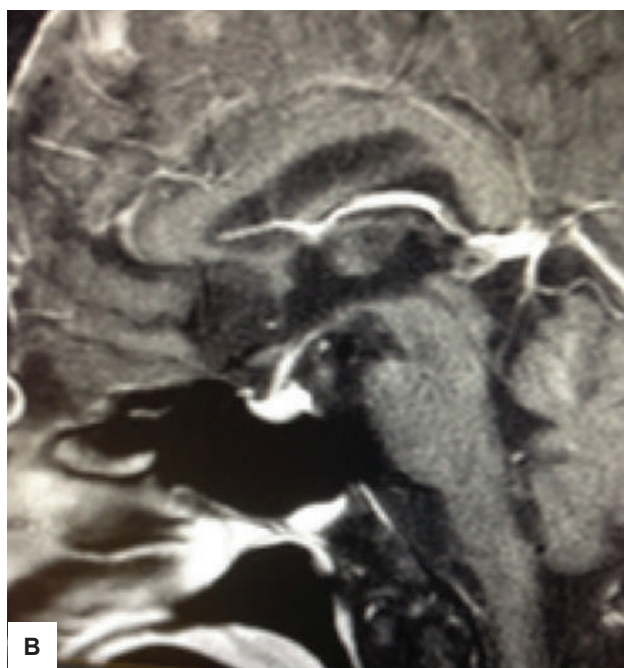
MRI of the pituitary showing small well-defined hypo to isointense nodules within the suprasellar region measuring 0.2x0.4x0.4 cm. (A) coronal view and (B) sagittal view.
